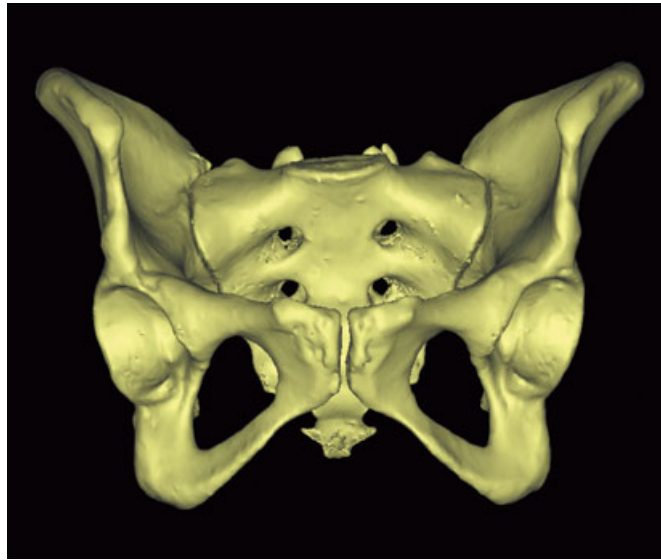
A virtual image of the pelvis created from CT data in the anterior view.
